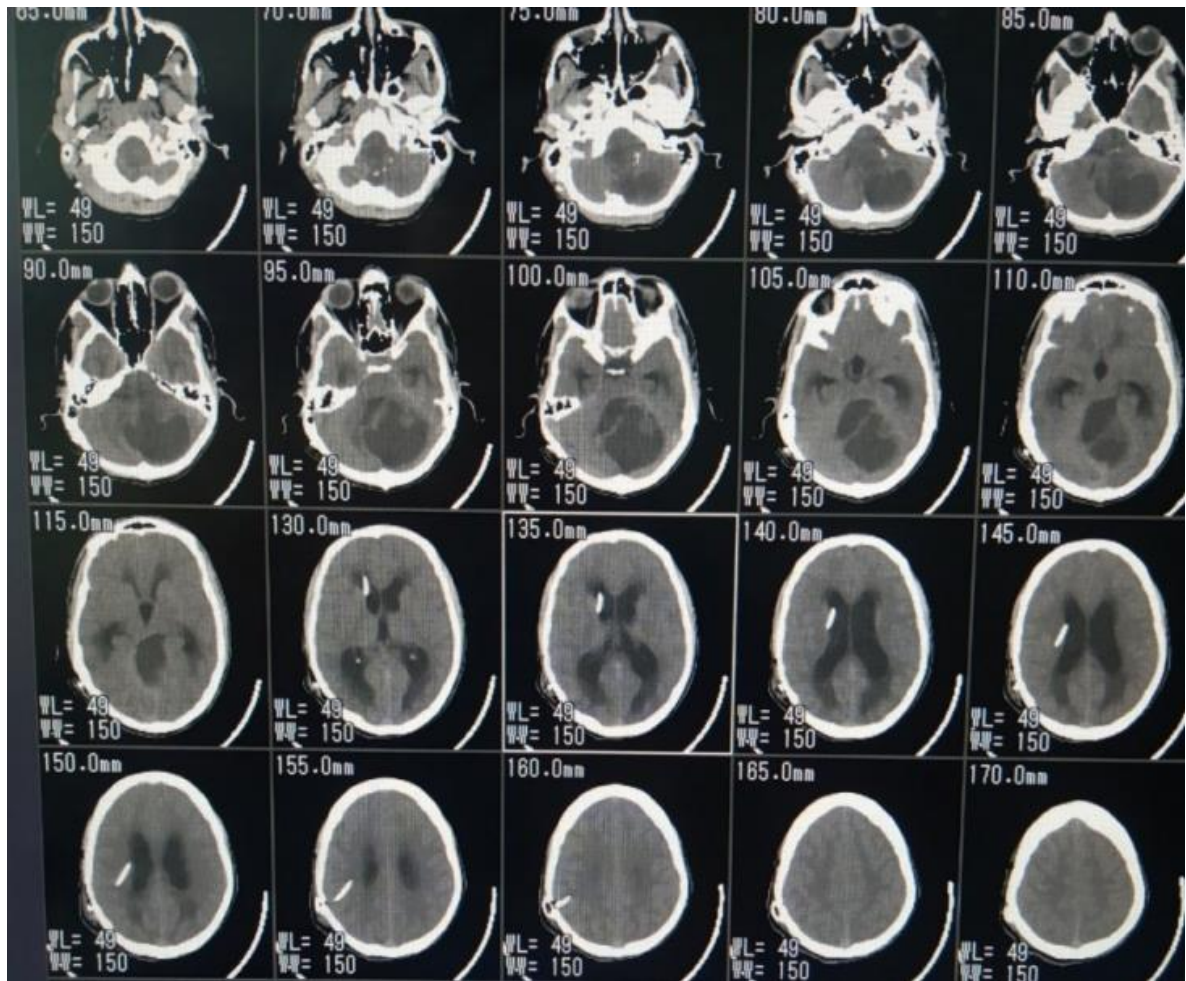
Post-operative CT brain after V-P shunt.
